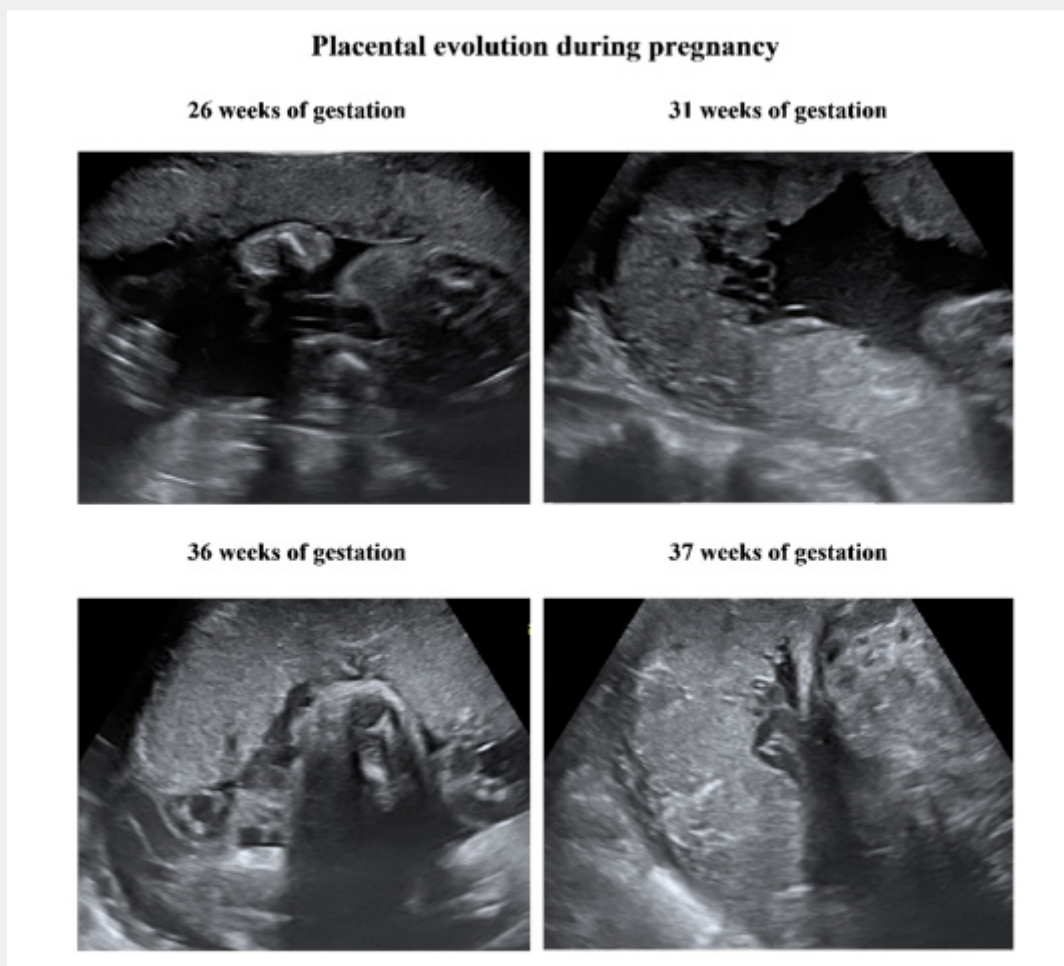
Ultrasonographic appearance of the placenta between 26 and 37 weeks of gestation.
